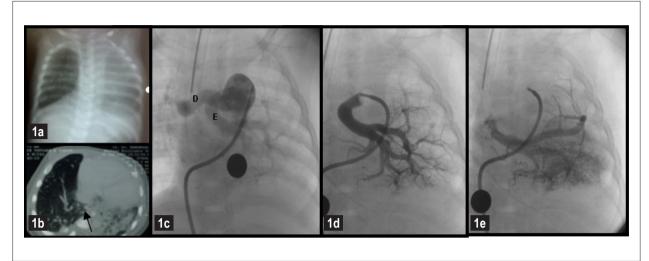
1a: Chest radiography in posteroanterior projection (PA) - shows deviation of structures from the mediastinum to the left hemithorax; 1b: Thorax tomography - pulmonary parenchyma in the thoracic midline (isthmus-arrow) and hypoplastic left lung; 1c: Angiography of pulmonary trunk in PA showing angiography of the pulmonary trunk in PA showing the right pulmonary artery (D) and its branch leading to the isthmus to the left lung (E); 1d: Selective angiography in this branch to the left lung - aberrant course and branches to the midline; 1e: Pulmonary isthmus venous return, which is parallel to the arterial branch, which drains into the left atrium.
